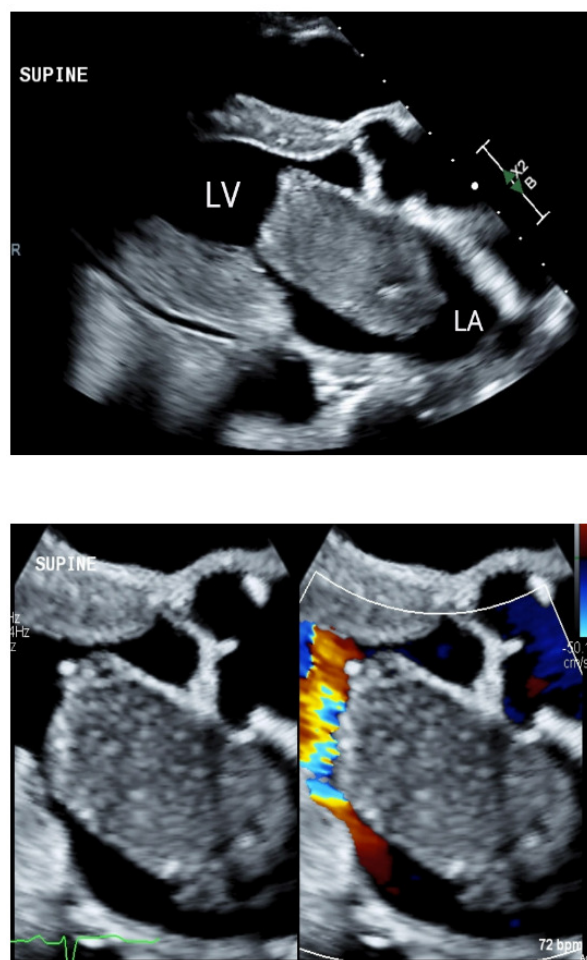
Top Panel: Parasternal View. Bottom Panel: (Left) Closer view to suspected myxomatous left atrial mass (Right): With color Doppler
